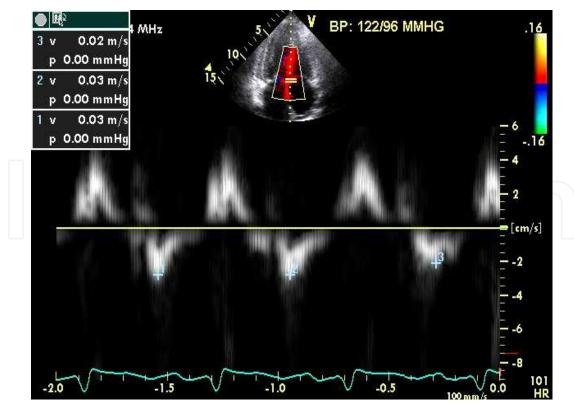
Tissue Doppler echocardiography showed only small mitral A waves but no A' waves in the mitral annulus
